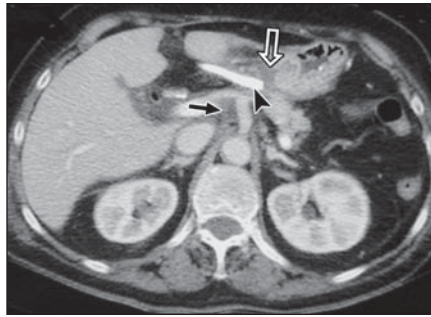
82-year-old woman 7 days after pancreaticoduodenectomy for duodenal adenocarcinoma. Transverse contrast-enhanced helical CT scan of abdomen shows no perianastomotic fluid collection at anastomosis (white arrow). Drainage tube (arrowhead) is next to anastomosis. Black arrow indicates perivascular cuffing around celiac trunk. Patient had clinicobiologic diagnosis of pancreatic fistula on postoperative day 7. Both radiologists correctly identified lack of perianastomotic fluid collection. Drain output established diagnosis of pancreatic fistula.
